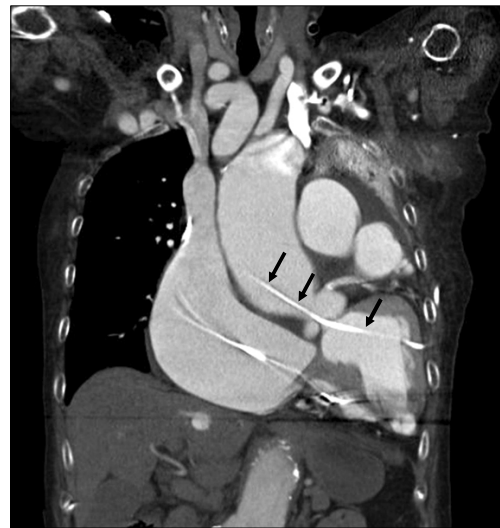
Computed tomogram of the chest. Both atria and great arteries were dilated and displaced to the left hemithorax with atelectasis of the left lung. The catheter tip was placed in the ascending aorta through the aortic valve and left ventricular cavity (arrows).
